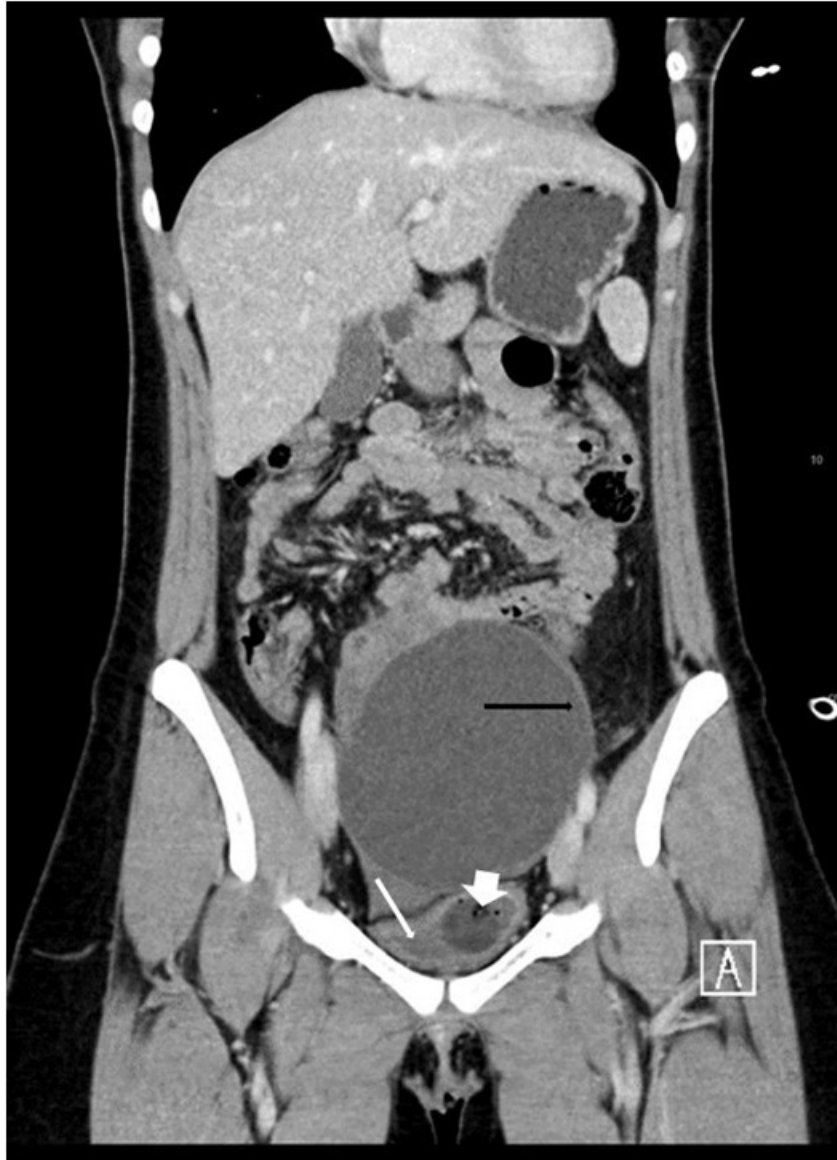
Computed tomography (CT) of abdomen and pelvis showing large ovarian cyst (black arrow) in relation to the bladder (slim white arrow) and urinary catheter (broad white arrow).
